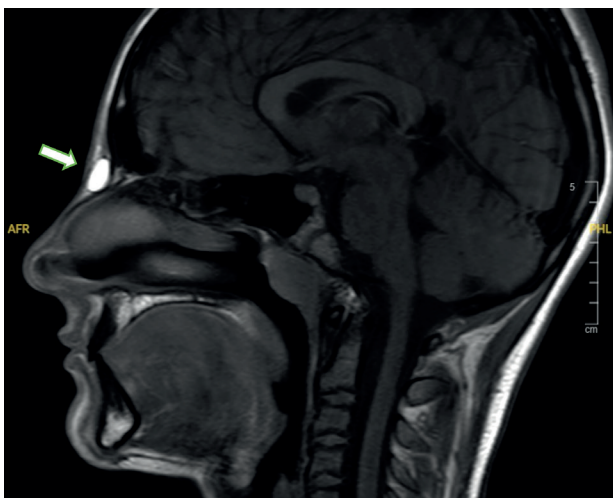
Sagittal T1-weighted MRI demonstrating a Type II nasal dermoid cyst
